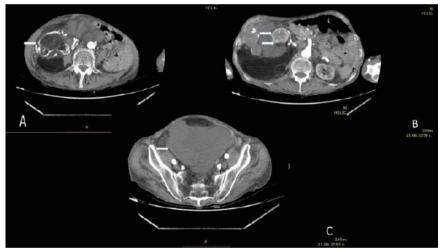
CT image of the patient with a retroperitoneal tumor mass. A – Hyperdense zone of the tumor located on the right side of the abdominal cavity. B – Part of the tumor showing evidence for possible infiltration of the right kidney. C – Hypodense zone of the tumor mass located in the pelvis without infiltration to adjacent organs.
